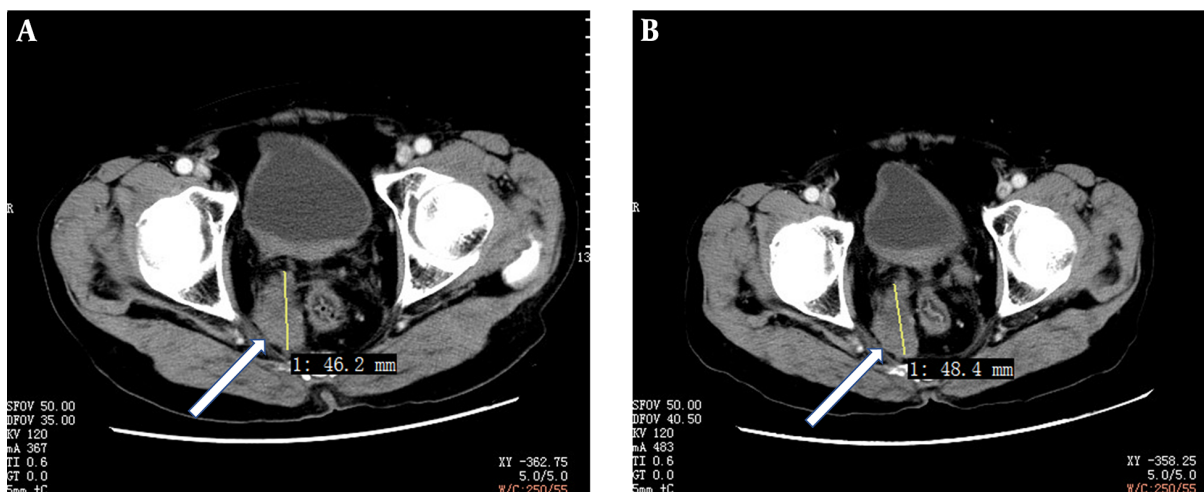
The CT images of rectal angiosarcoma. A, before treatment; B, nine months after treatment with apatinib; red lines indicate the size and borders of the mass.
